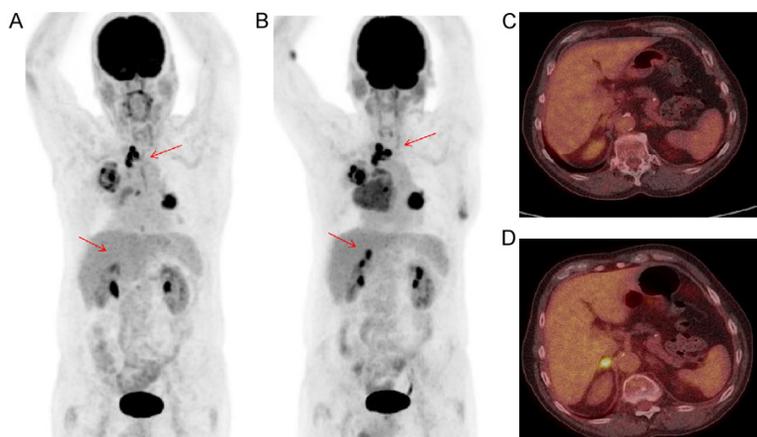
Patient example with whole body PET scan and trans axial fused PET/CT: A 69-year-old male before (A and C) and after 12 days of erlotinib treatment (B and D), with progression for all methods with new lesions in both the right adrenal gland (D) and a thoracic lymph node. Red arrows indicate the lesions with the highest impact on the response evaluations.
